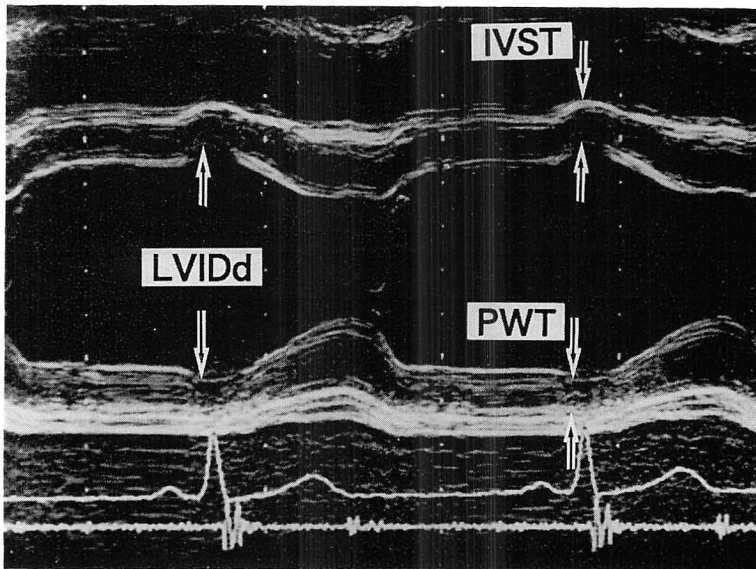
M-mode echocardiographic measurements.
